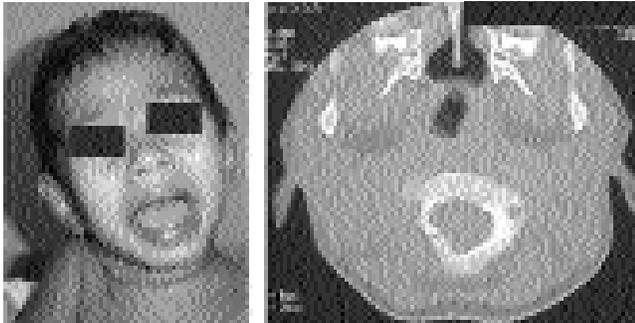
Clinical photograph showing torticollis (left), CT scan bone window showing fracture of C3 lamina or right side (right).
